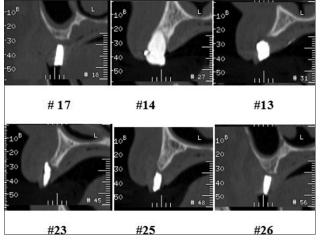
Maxillary computed tomography scan
